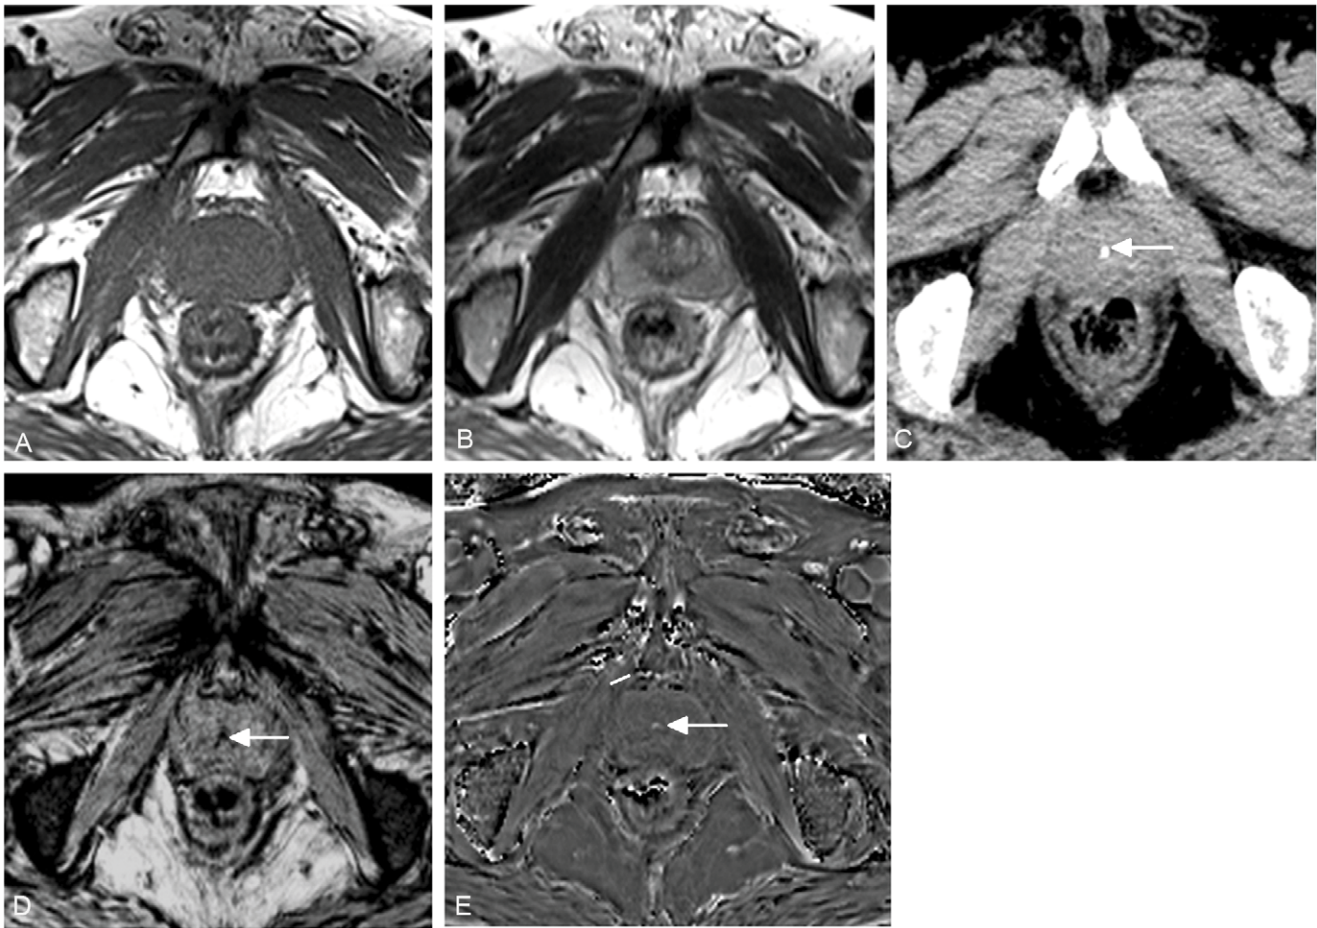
A 62-year-old man with benign prostatic hyperplasia. No prostatic calcification is demonstrated on conventional T1WI (A) and T2WI (B), but dot-like high density on CT (C), low signal on SWI (D) and high signal on filtered phase image (E) (arrows) indicates calcification. doi:10.1371/journal.pone.0053237.g004
